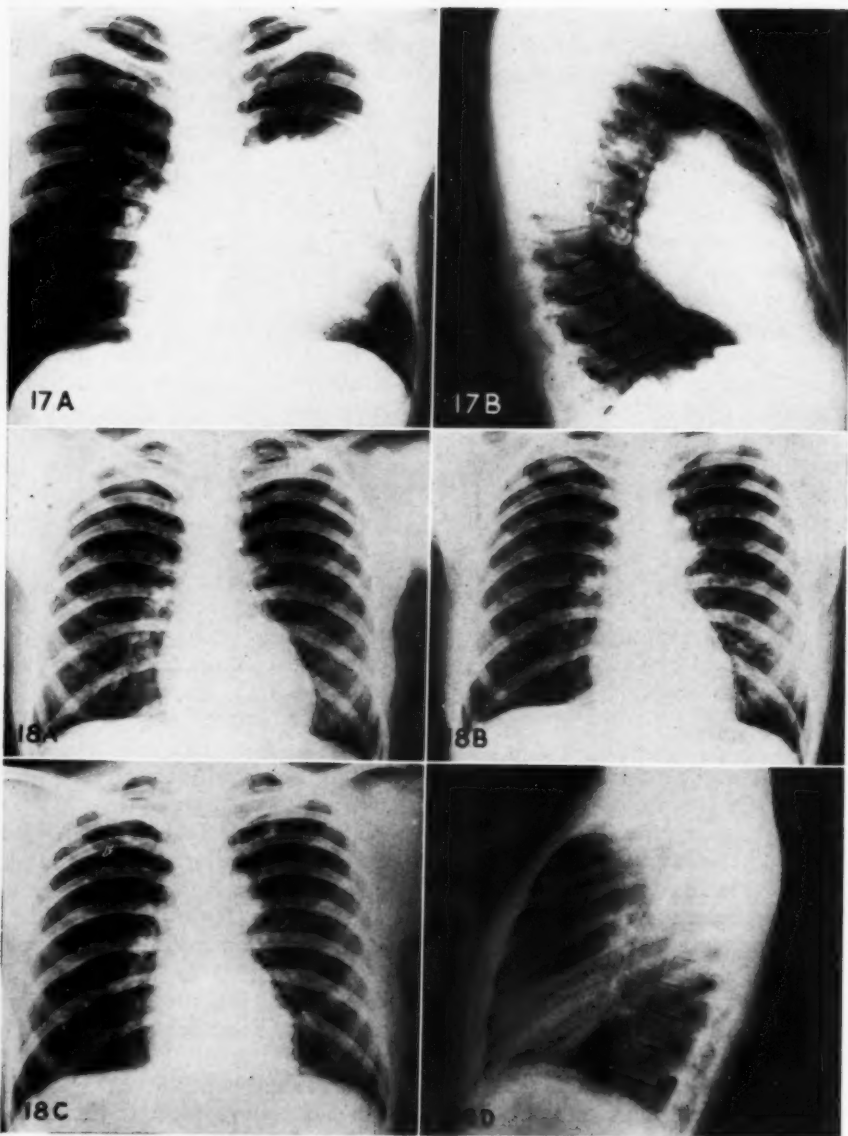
Dermoid cyst of the mediastinum. White male, age 29. X-ray examination of the chest during an acute respiratory infection revealed a mass in the left side. A. Frontal view. B. Lateral view, demonstrating the anterior location and showing plaques of calcification along the borders of the tumor. The location, the relative lack of symptoms in spite of the large size of the tumor, and the calcification along the margins make the diagnosis of dermoid almost certain. The tumor was removed successfully.
